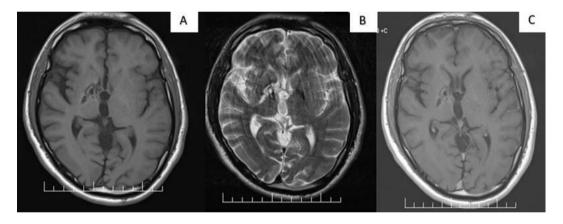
Cranial MRI of the previously treated basal ganglia germinoma at the last follow-up demonstrates stable disease with surrounding gliosis and post-radiation changes with secondary ex-vacuo dilation of the ipsilateral frontal horn of the lateral ventricle in T1 and T2-weighted images (A & B). No new lesion was detected in the post-contrast T1-weighted image (C).
